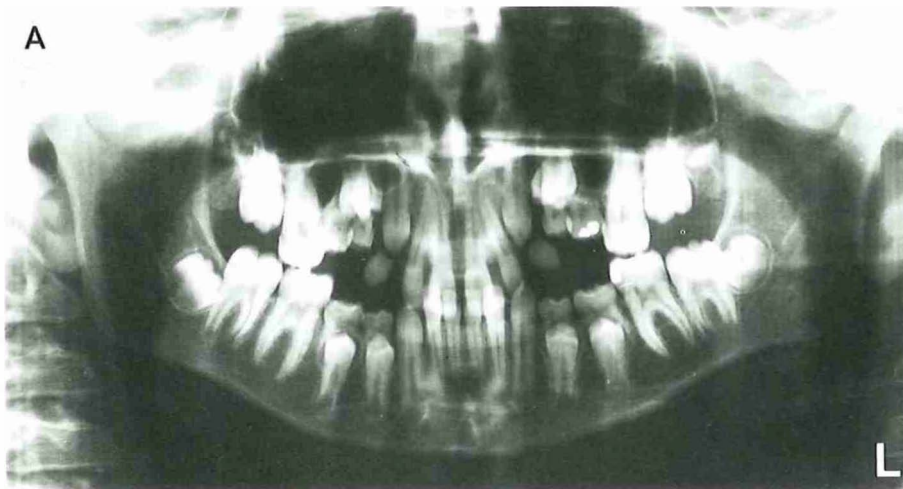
A Orthopantomogram of a 10-year-old boy with secondary retention of all deciduous molars.
